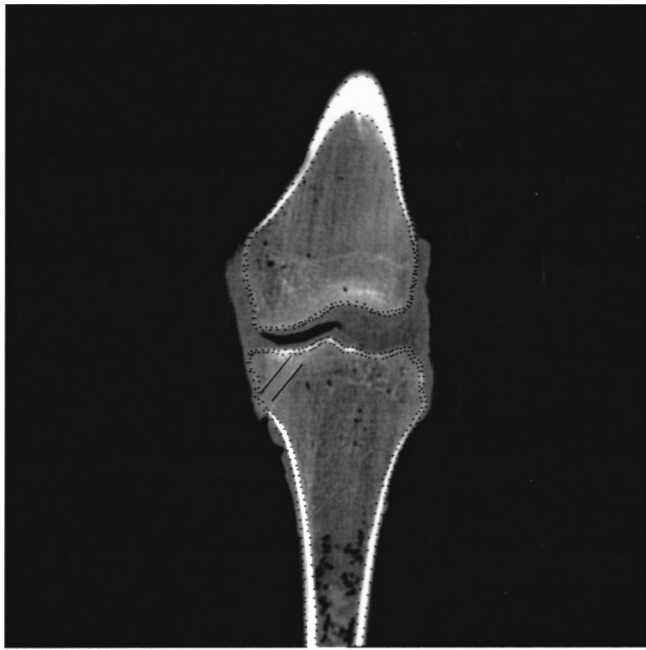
Representative helical CT image used to obtain bone geometry with the points used for digitization. Solid lines represent the edges of the rods used for tissue geometry registration. Note that only one rod can be seen in this scan.
